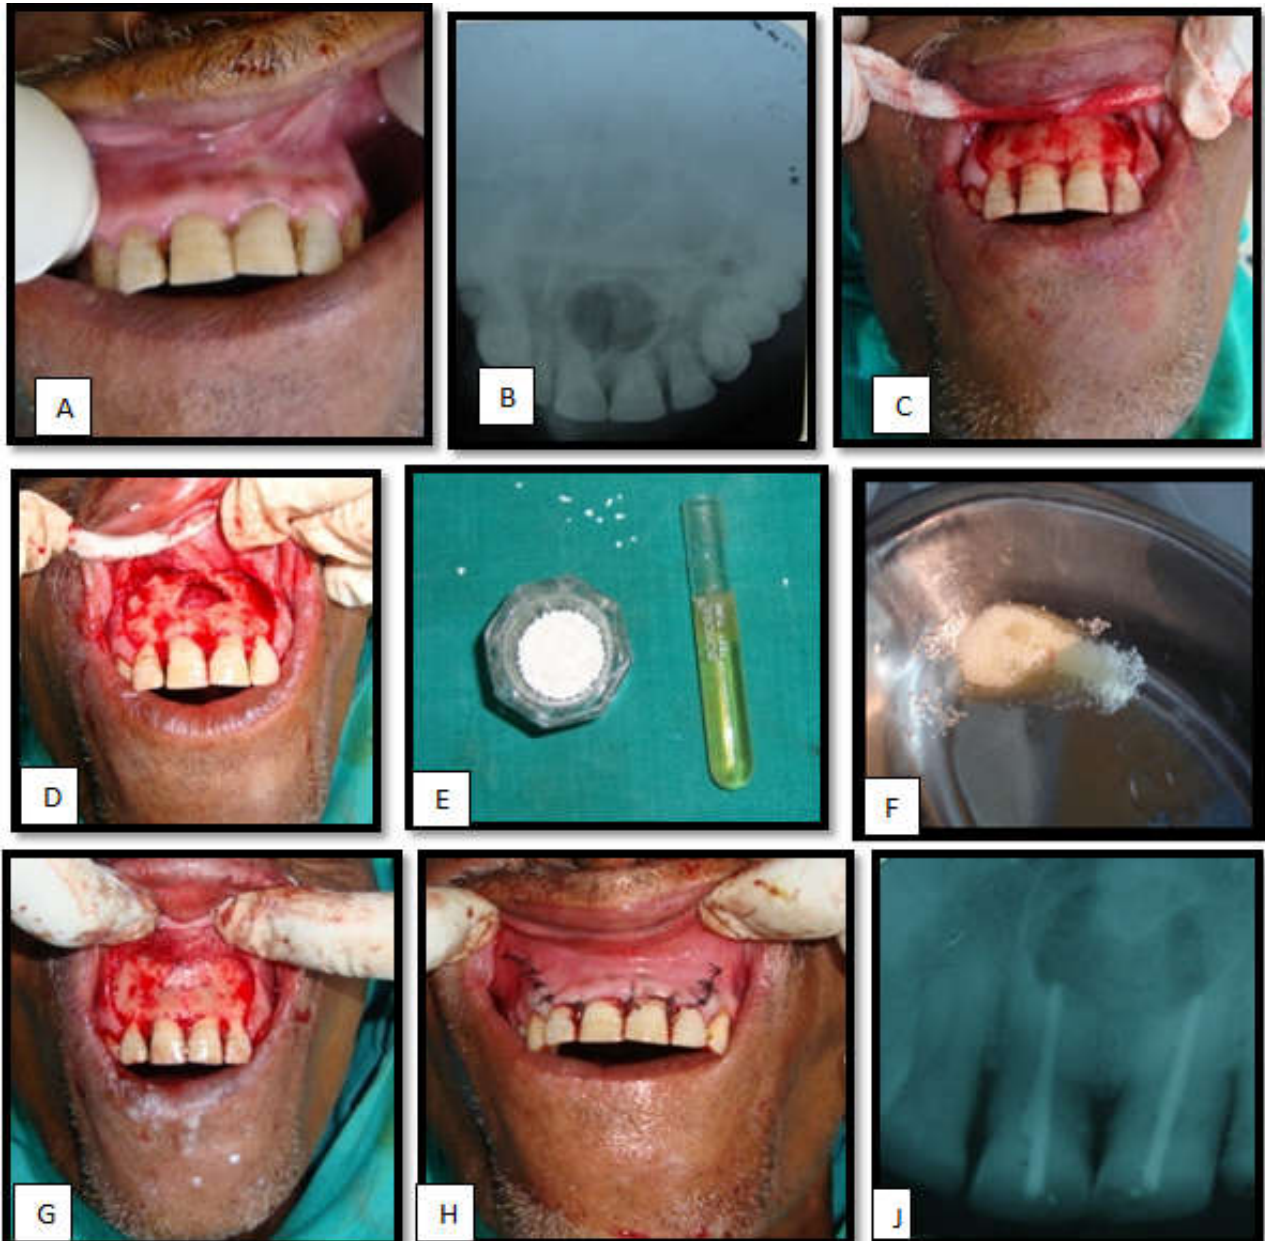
Apicoectomy (maxillary central incisors) defect closed with PRP & hydroxyappetite. A. Preoperative view Intraorally. B. Preoperative view Intraorally . C. Trapezoidal Incision given and mucoperiosteal flap raised intraorally. D. Cyst excised. E. PRP and hydroxyappetite. F. Platelet rich plasma gel mixed with hydroxyapatite. G. PRP placed in defect. H. Closure done with 3-0 silk suture I. Postoperative IOPA X-ray
